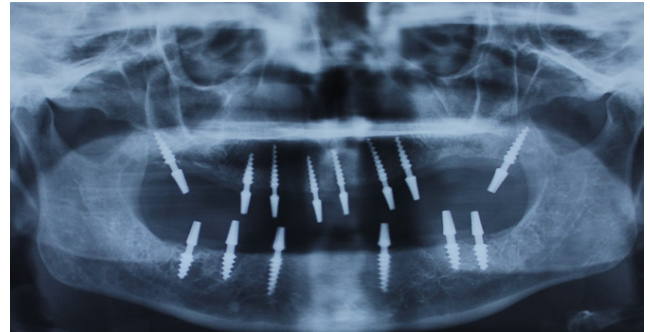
Post operative radiographic view
